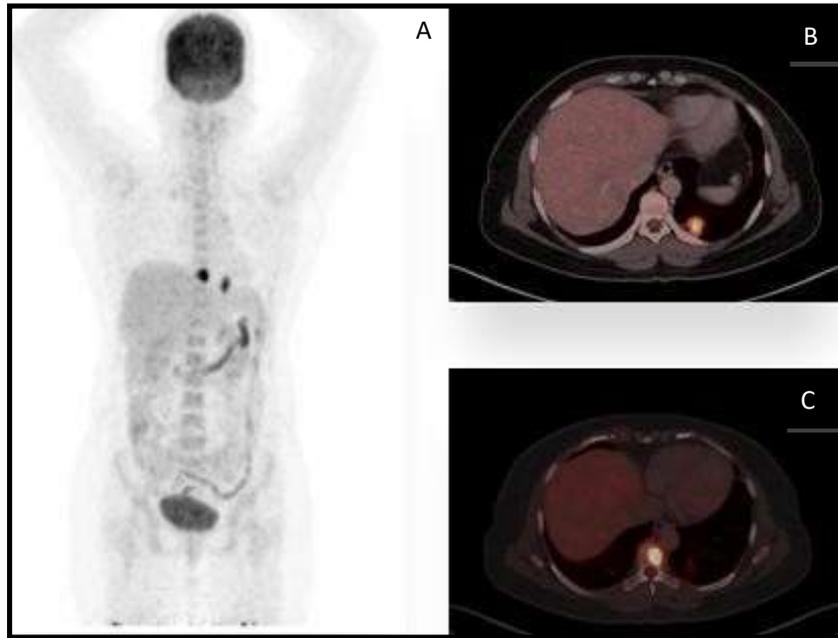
A- MIP image, B- Fusion image of ^{18}F -FDG PET/CT in a 51 year old female with poorly differentiated lung adenocarcinoma of lower lobe of left lung, measuring 1.9x 1.8 cms. SUV_{max} - 9.8, SUL_{peak} - 6.9, SUV_{mean} - 5.9, MTV - 3.1, TLG - 18, with solitary skeletal metastasis (Stage IVA). C- Metabolically most active skeletal metastasis in D8 vertebra. The patient tested positive for ALK mutation.
